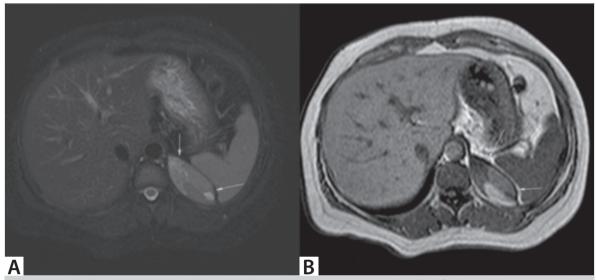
Axial turbo spin-echo T2-weighted A. and T1-weighted B. images reveal a well-defined, ovoid, heterogenous lesion with hyperintense components (arrows) in the left suprarenal region abutting the diaphragmatic crus.
